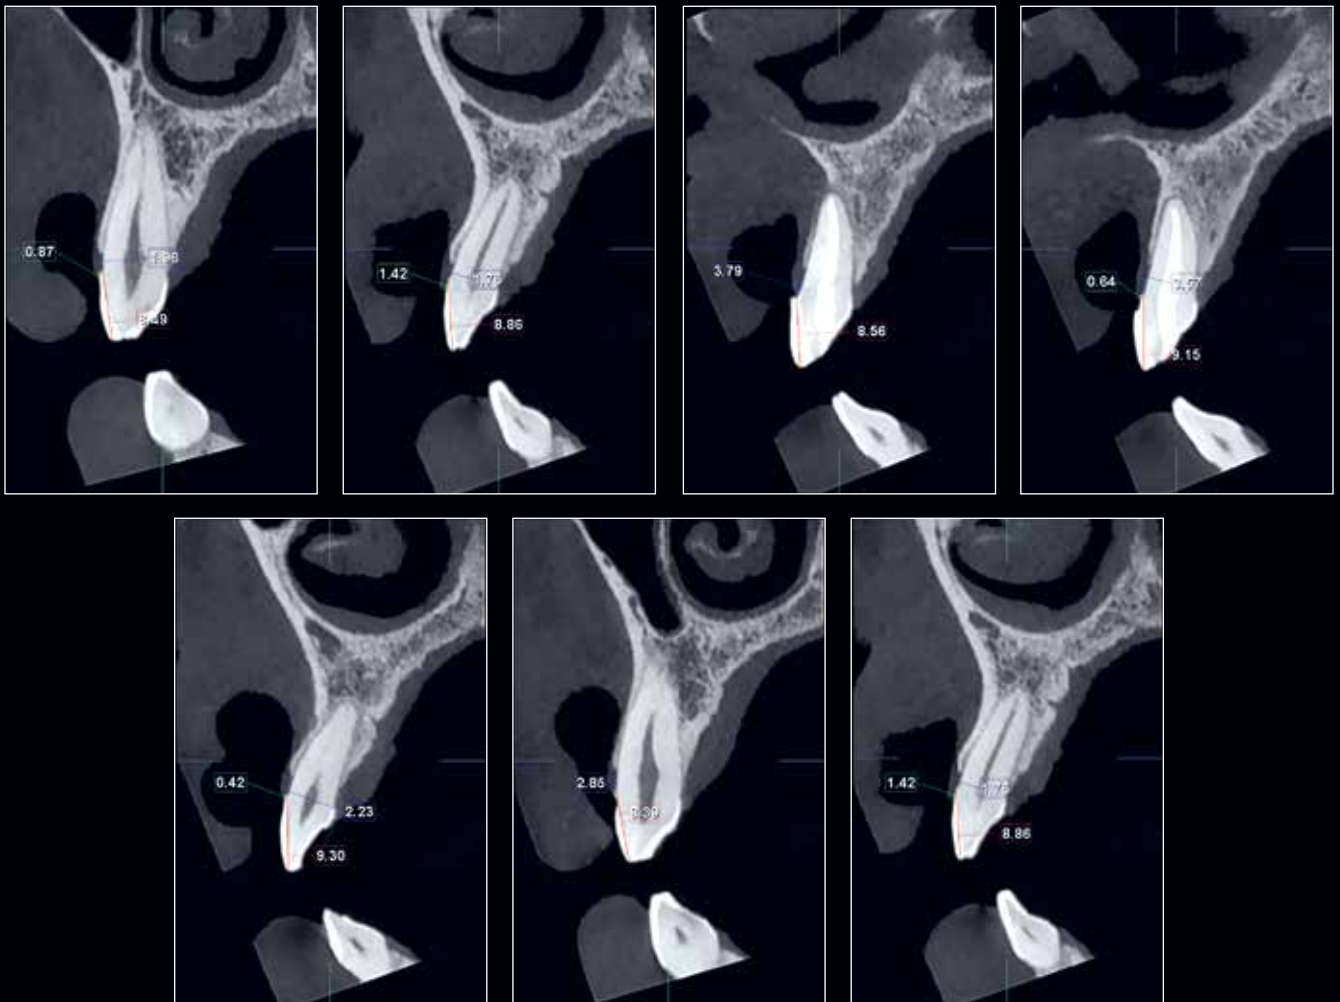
CBCT evaluation of the maxillary anterior teeth.
